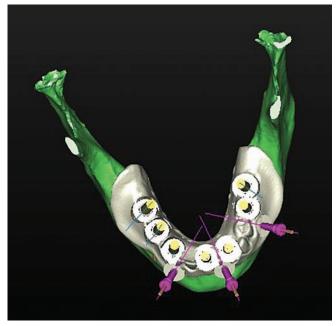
J, This view shows the surgical guide stent on the virtual plan. The CT planning software provides a view of the proposed guide stent for final review before its fabrication. The sleeves are visible in the planned implant locations as well as the stabilizing pins.
